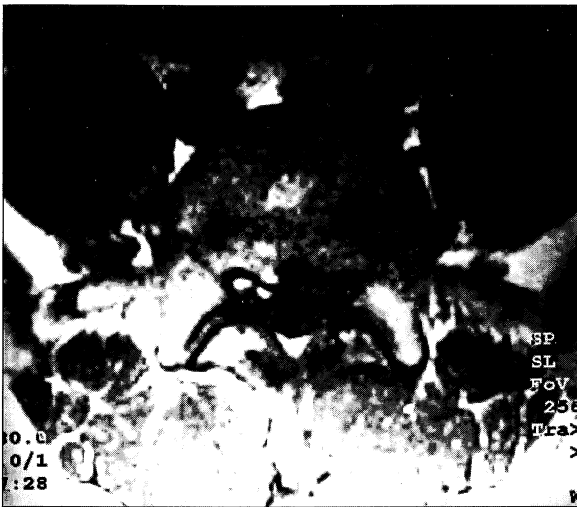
Axial T1-weighted scan showing a lesion effacing the epidural fat on the left side of the spinal canal
